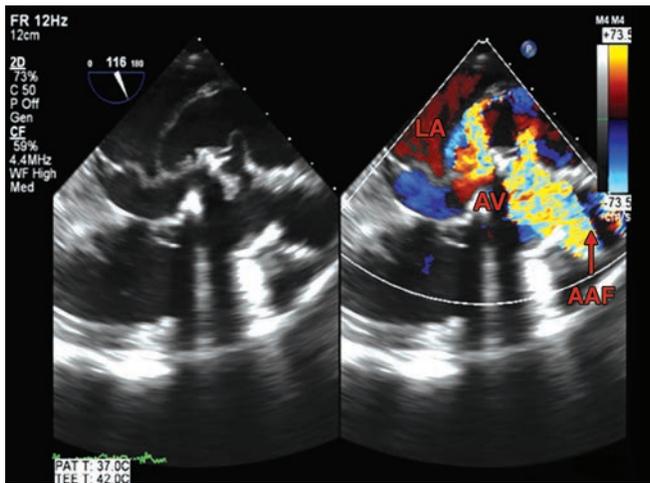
TEE (long axis and short axis views) showed an aortic root abscess around a bioprosthetic aortic valve forming a fistulous communication to the left atrium. A color flow Doppler showing blood flow from the bioprosthetic aortic valve, into the aortic root abscess, which has ruptured into the left atrium, forming an aortico-left atrial fistula. There is a paravalvular aortic regurgitation.
